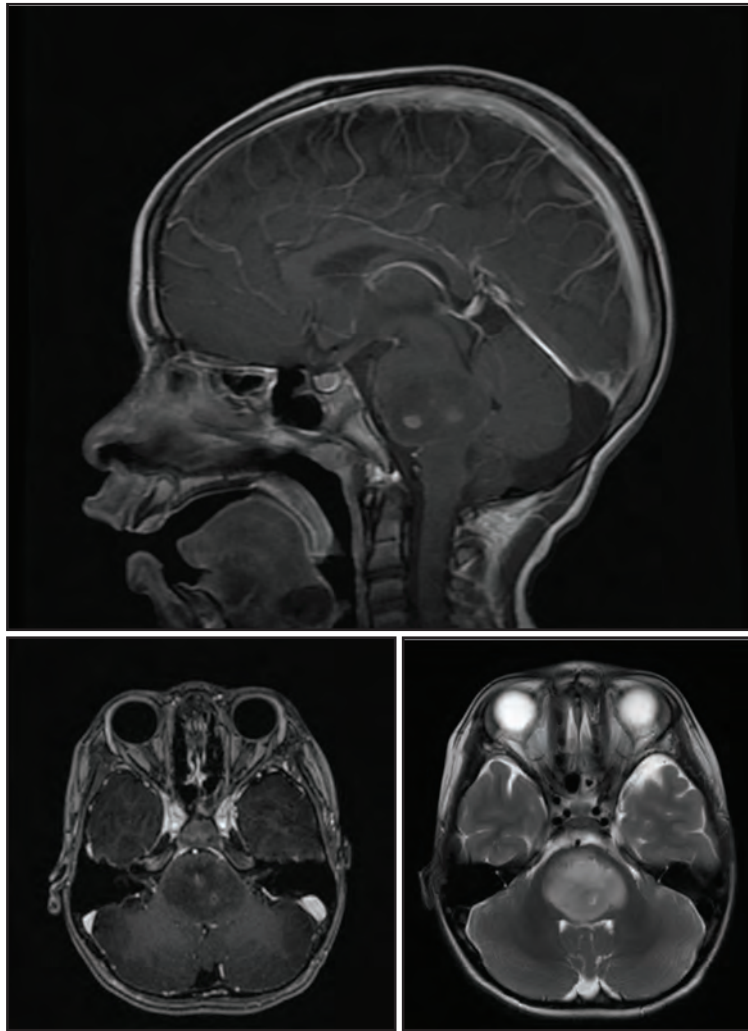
Appearance of DIPG on T1 and T2 MRI sequences in sagittal and axial sections
